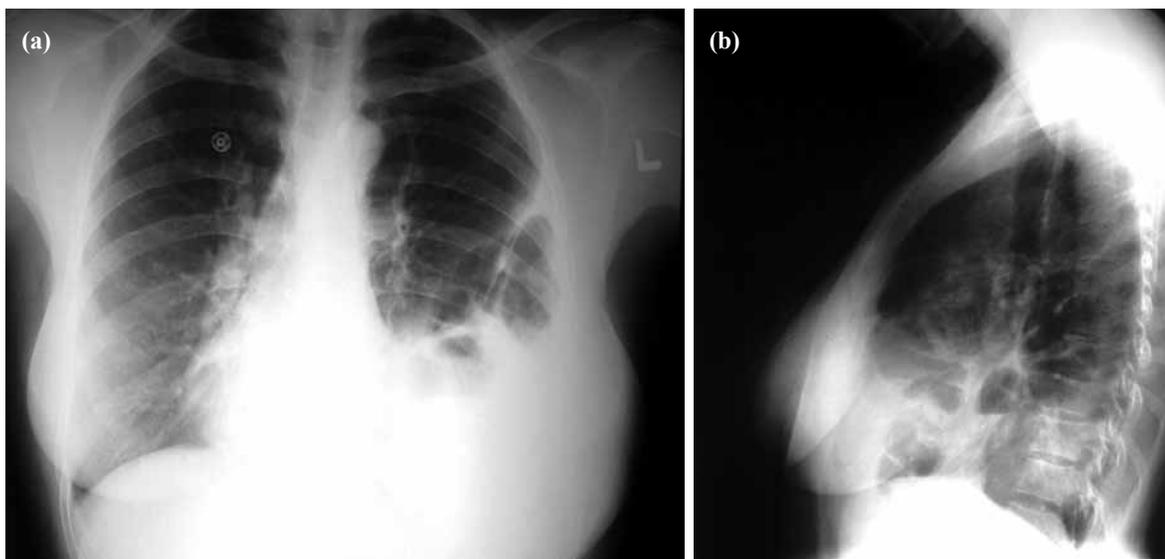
Left TDR in a 38-year-old woman following a traffic accident. Chest X-ray (18 hours following the accident) shows herniation of the splenic flexure of the colon in the left hemithorax: (a) posteroanterior view and (b) lateral view.
